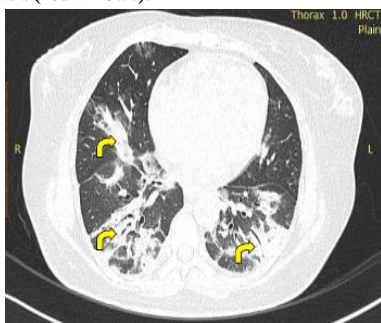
Axial HRCT images show patchy areas of consolidations (curved arrows) in both lung fields (both lower lobes and right middle lobe) in peribronchial location
